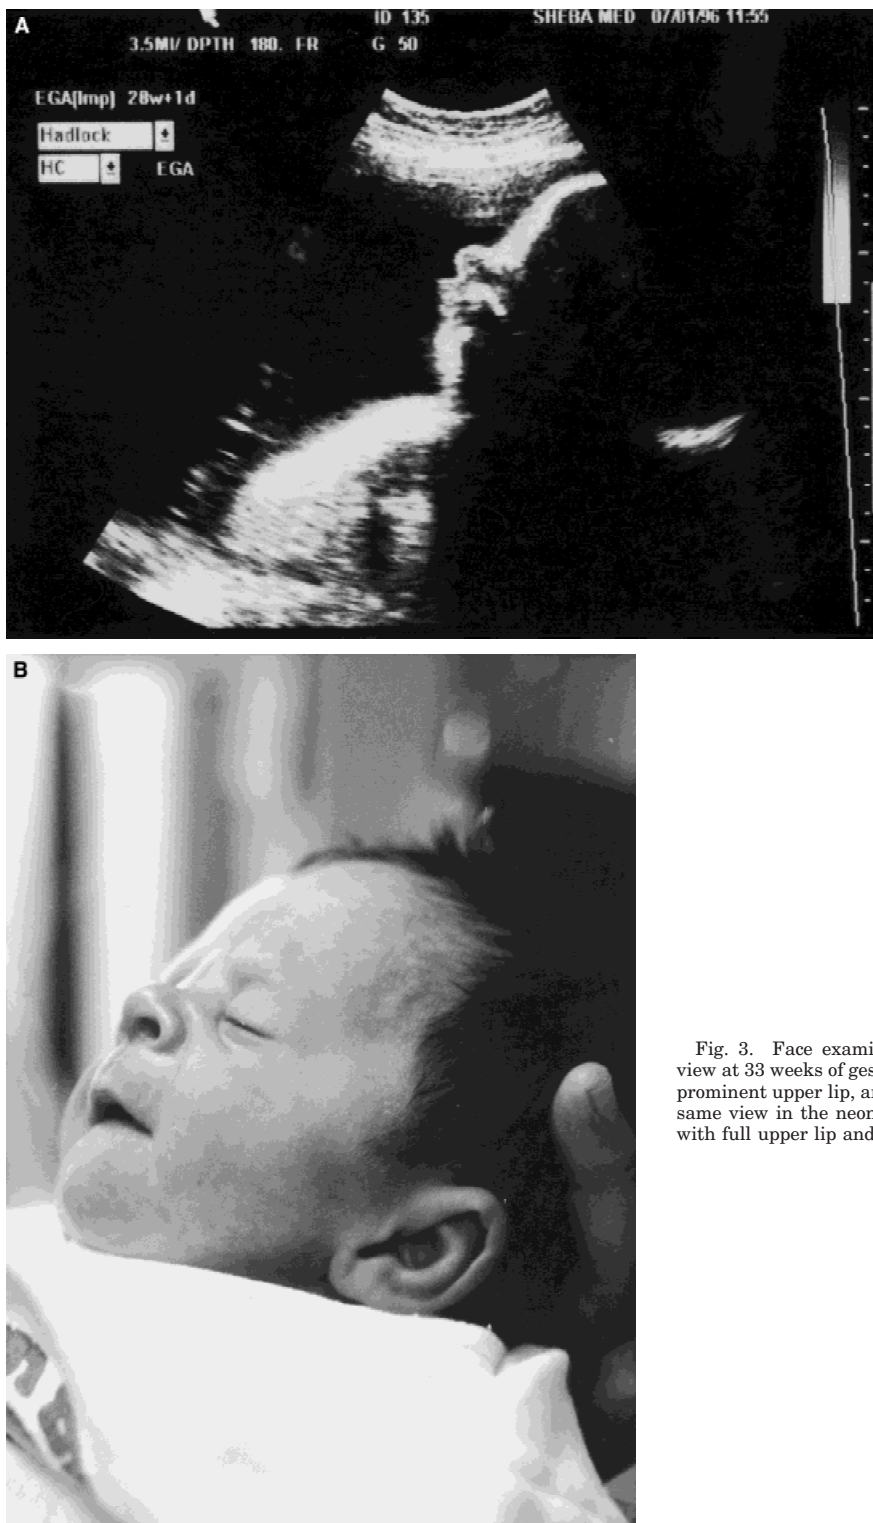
Face examination of Patient 2. A: Sagittal ultrasonographic view at 33 weeks of gestation reveals upturned nose, depressed nasal root, prominent upper lip, and mild retrognathia can be demonstrated. B: The same view in the neonate shows apparently low-set ears and small chin with full upper lip and depressed nasal bridge.
